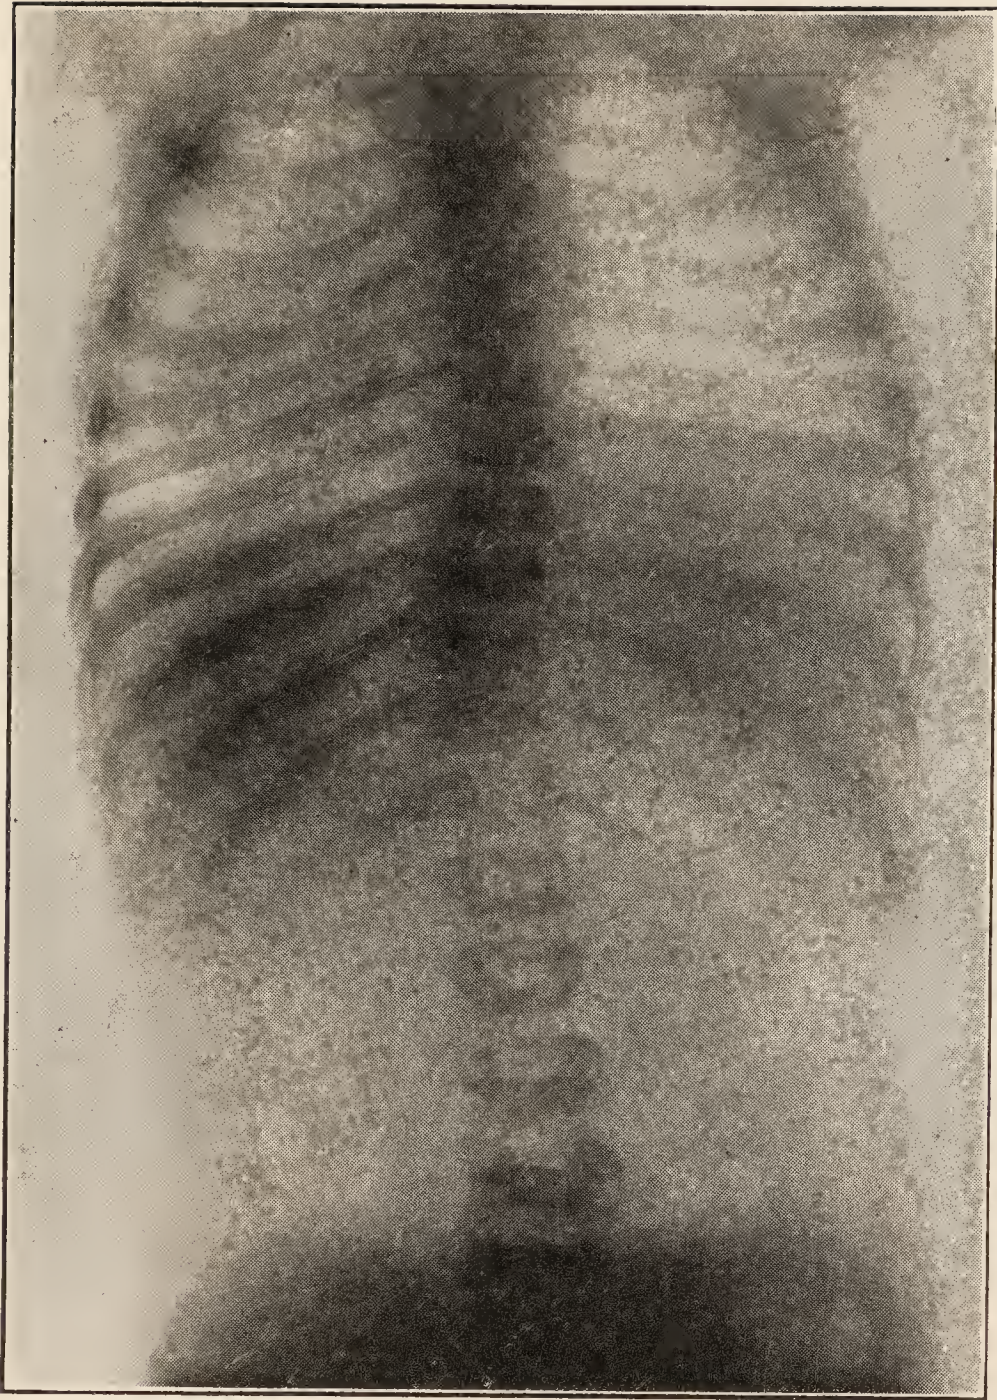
X-ray of patient shown in Fig. 65 after six months' treatment by forcible jackets.
